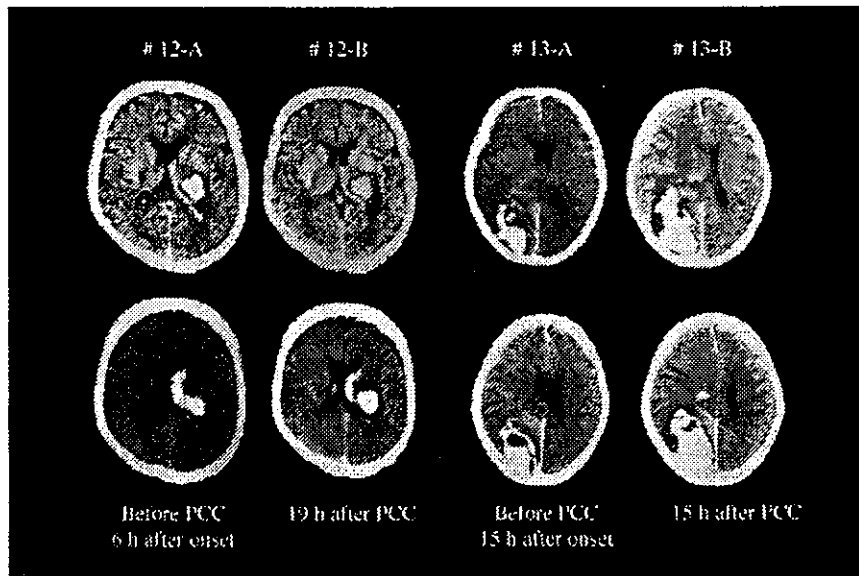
Brain CT images of patients #12 and #13; #12-A, 6 h after onset and before PCC administration; #12-B, 19 h after PCC administration; #13-A, 15 h after onset and before PCC administration; #13-B, 15 h after PCC administration.
